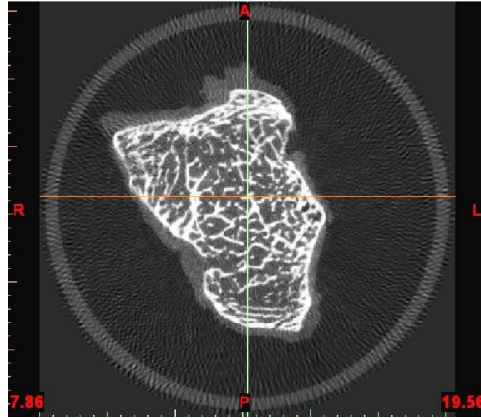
2D slice through a  $\mu$ CT-volume image of bone and articular cartilage. The imaged cartilage (bone tissue shown in white, cartilage in soft grey surrounding the bone outline) can be represented as a height-field on the supporting bony surface. The height-field is defined as a collection of base points on the bone surface, the bone surface normal at that point, and the height along the normal at which the normal intersects the cartilage external envelope.
